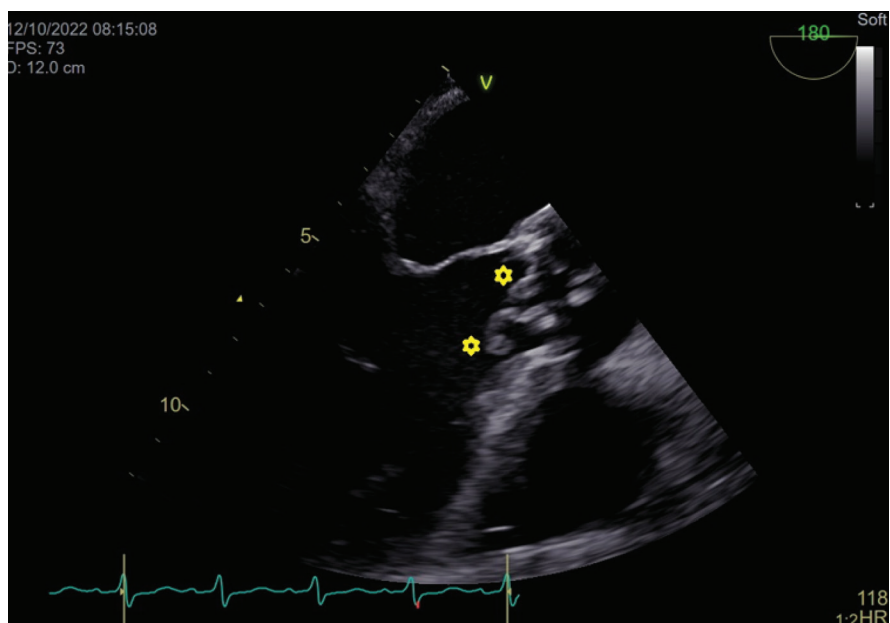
Transesophageal echocardiography (mid-esophageal, long axis, 180°): two large fresh hypermobile vegetations attached to aortic cusps.
